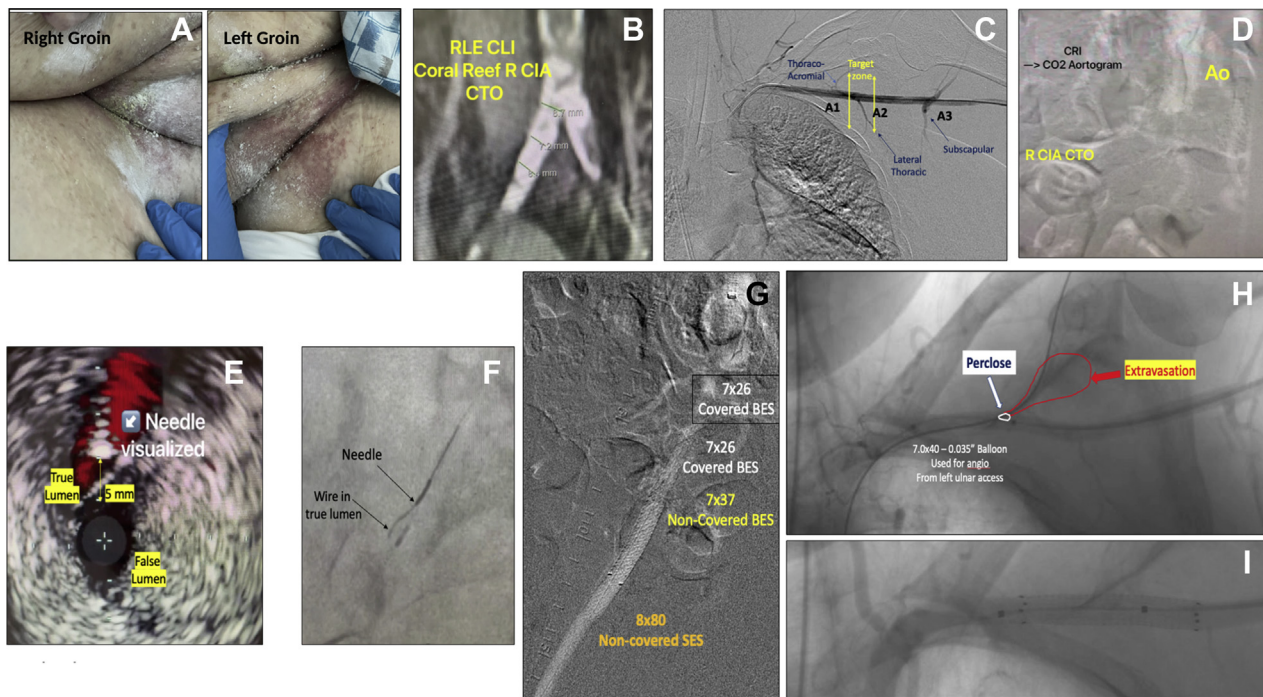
(A) Hostile groins: Bilateral severe fungal cellulitis treated with nystatin powder. (B) CT angiography of the abdominal aorta with runoff: Focus on the heavily calcified occlusion of the right common iliac artery. (C) Percutaneous left axillary artery access: Angiography performed from a left ulnar artery access to guide percutaneous left axillary artery access. (D) Aortogram with CO₂ gas: Flush occluded bilateral CIA. (E) The IVUS image showing precise needle re-entry. (F) The fluoroscopic image of the needle and 0.014" wire entering the true lumen in the external iliac artery. (G) CO₂ iliac arteriogram: Reconstruction of the iliac CTO with different stent types in the different segments of right CIA and external iliac artery. (H) Axillary arteriogram after first attempted percutaneous closure: Persistent extravasation after cinching the nonlocking suture of the Perclose ProGlide device (Abbott Vascular). (I) Axillary artery covered SES: The extravasation of contrast completely resolved after deployment and after dilation of a 7 × 50 mm Viabahn stent (Gore Medical). Ao, aorta; BES, balloon-expandable stent; CIA, common iliac artery; CLI, critical limb ischemia; CRI, chronic renal insufficiency; CT, computed tomography; CTO, chronic total occlusion; IVUS, intravascular ultrasound; SES, self-expanding stent.
